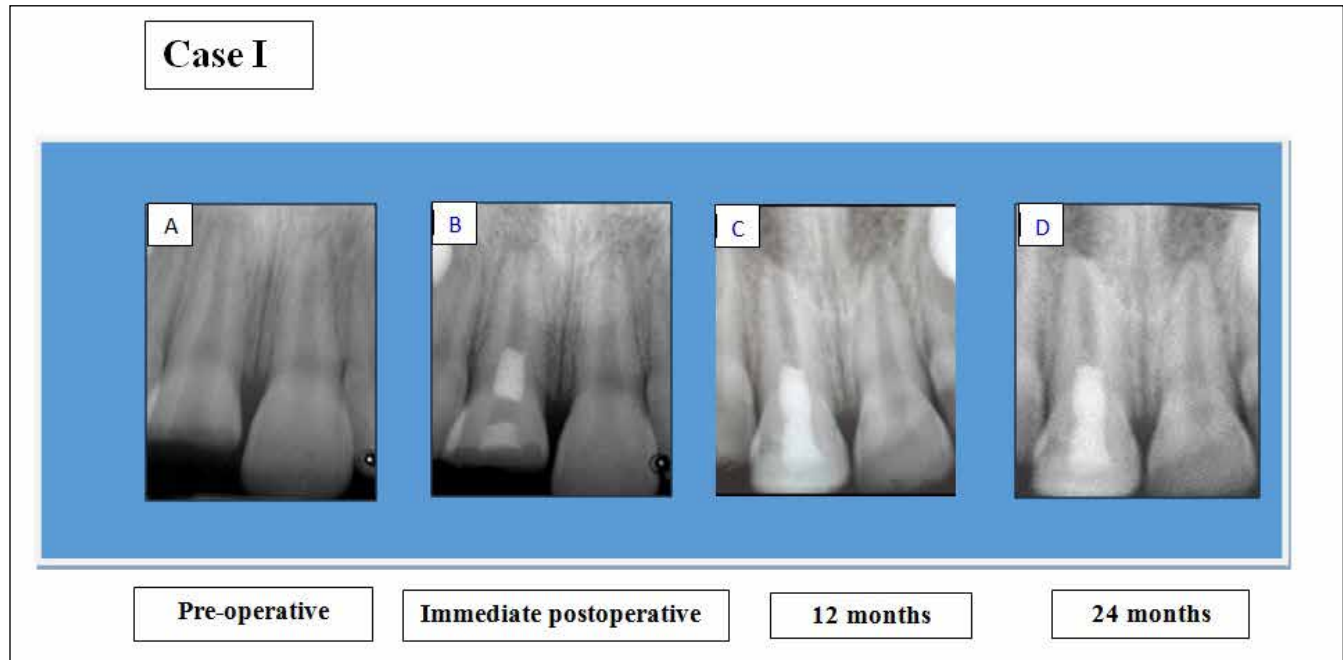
(A) Preoperative radiophotographs showed tooth # 11 having open apex with periapical radiolucency. (B) Immediate postoperative radiophotograph. (C) 12 month postoperative radiophotograph showing disappearance of periapical radiolucency. (D) 24 month follow-up radiophotograph revealing maturation of root with thickening and lengthening of the dentinal walls.
